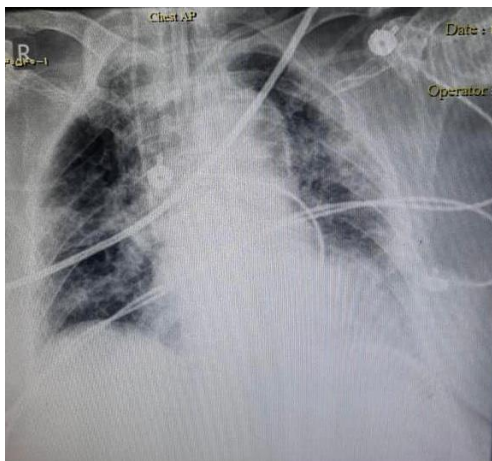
Patient chest x-ray; disseminated patchy opacities are shown
